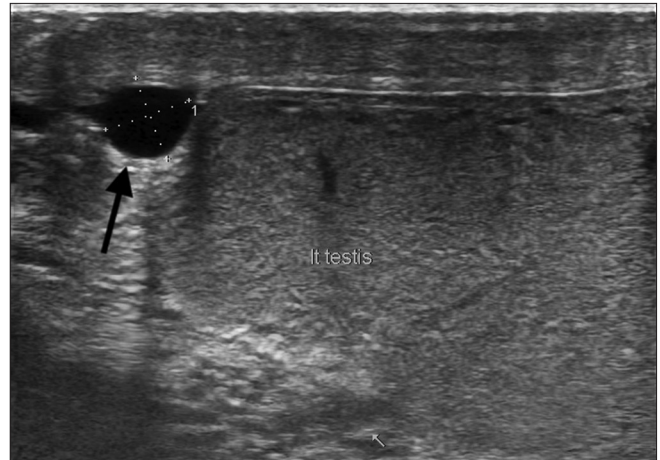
Greyscale Ultrasound image of upper pole of left testis
